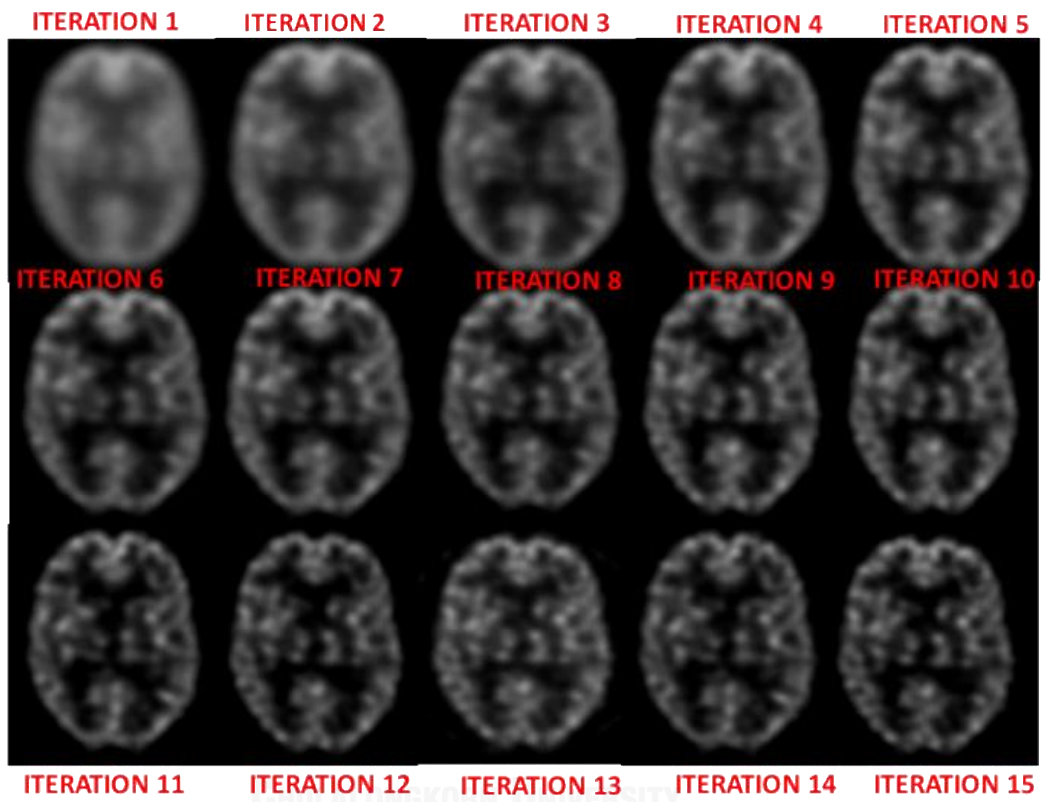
Figure B 1. The brain SPECT images by varying number of iterations in low activity concentration (3D- OSEM)
